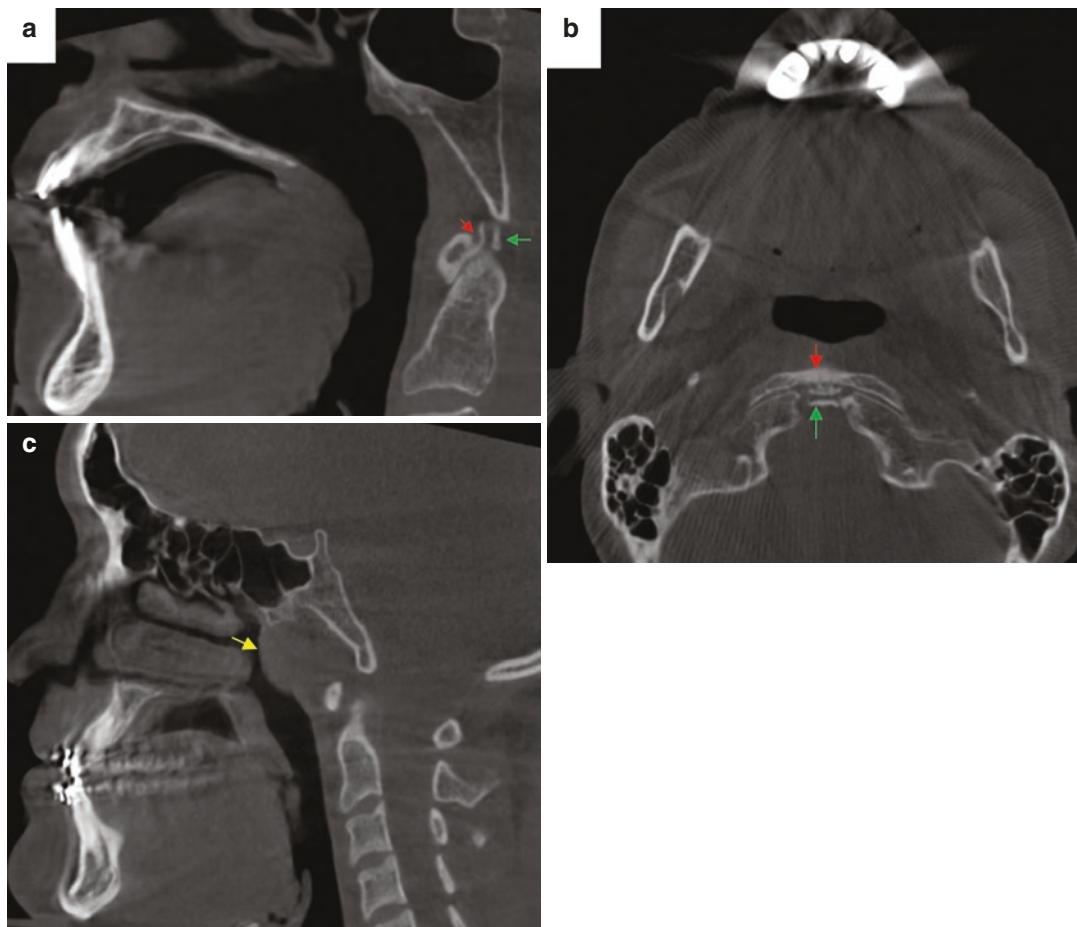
CBCT views show normal unobstructed airway on sagittal view (a) and axial view (b). Enlarged adenoids causing narrowing of the airway are shown by the yellow
